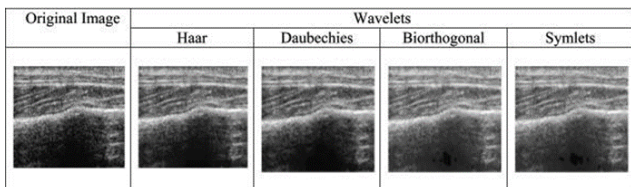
Rib fracture ultrasound image.
